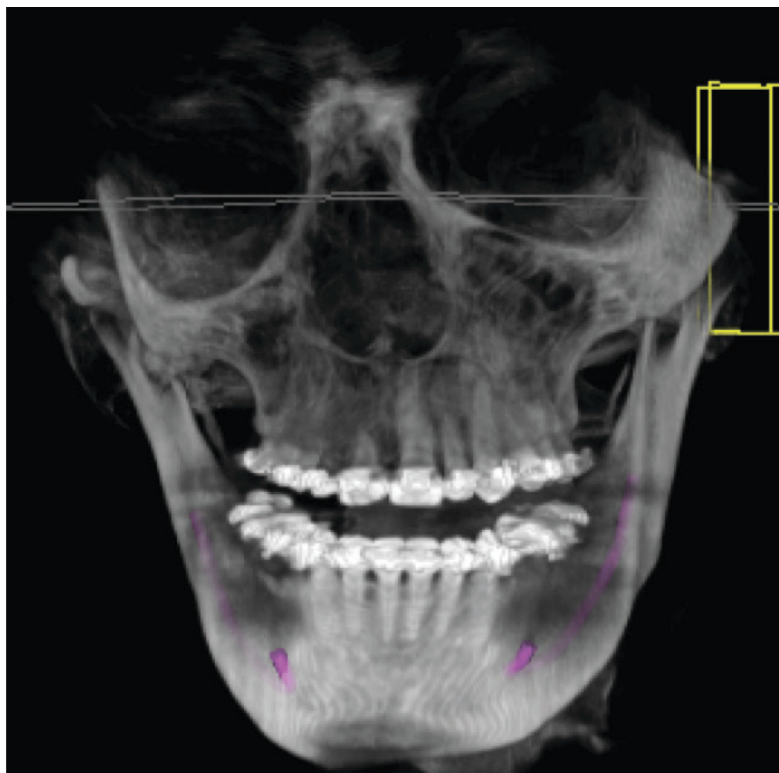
Pre-operative computed tomography shows severe right side malar hypoplasia, paranasal deficiency, agenesis of the zygomatic arch, deviated maxilla, and edged towards the right side.
